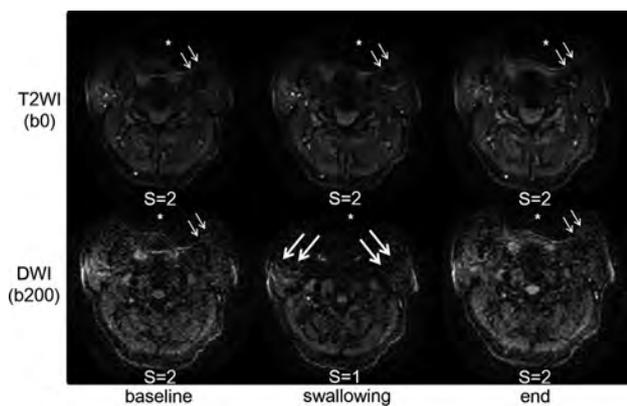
Magnetic susceptibility artifacts involving the bilateral masticator spaces and parotid glands (*long arrows*) are observed during swallowing on DWI in a volunteer with metallic dental implants. Artifacts involving the oral cavity (*stars*) and left masticator space (*short arrows*) are evident on all T2WI and DWI. S indicates magnetic susceptibility artifact score.
